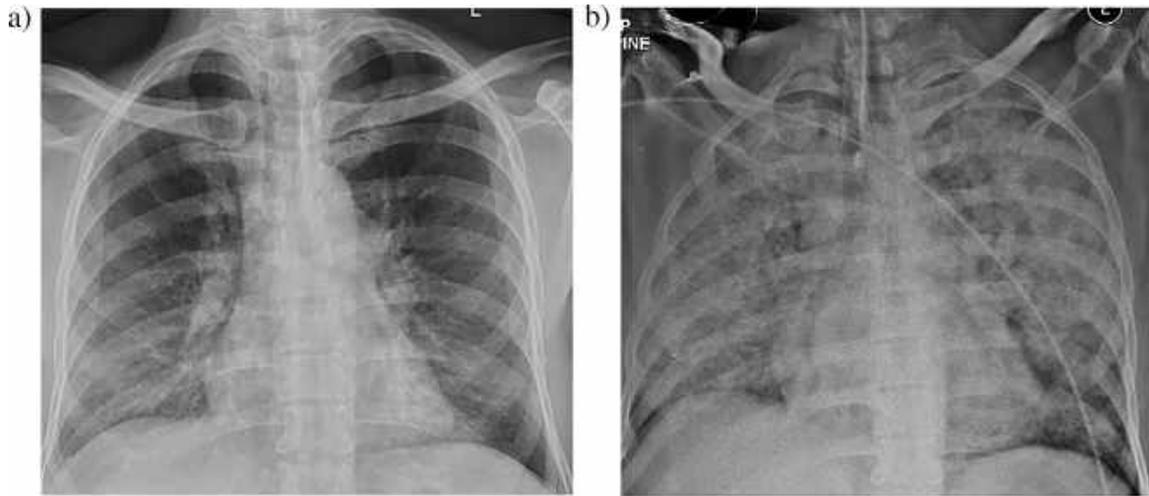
(a) Chest X-ray showing bilateral Hilar prominence (b) showing diffuse infiltrative lesions involving entire lung fields.
